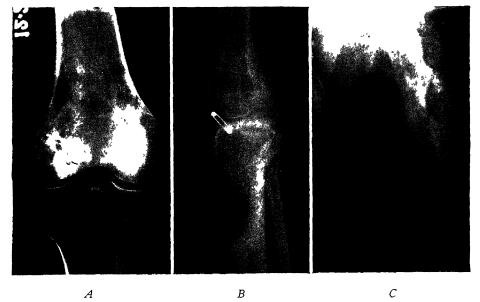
1, Roentgenogram of femur. B, Roentgenogram of tibia. C, Roentgenogram of humerus. (Parker and Jackson. Surg., Gynec. & Obst.)
